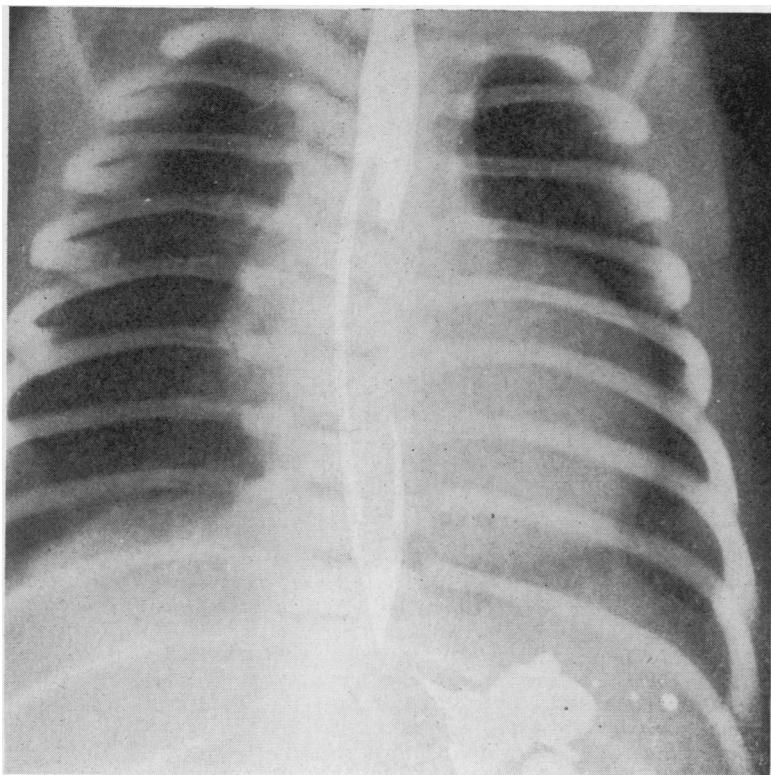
Case 2. Frontal chest radiograph. Decreased pulmonary vascular markings, left ventricular enlargement, and lack of prominence of pulmonary arterial segment.
